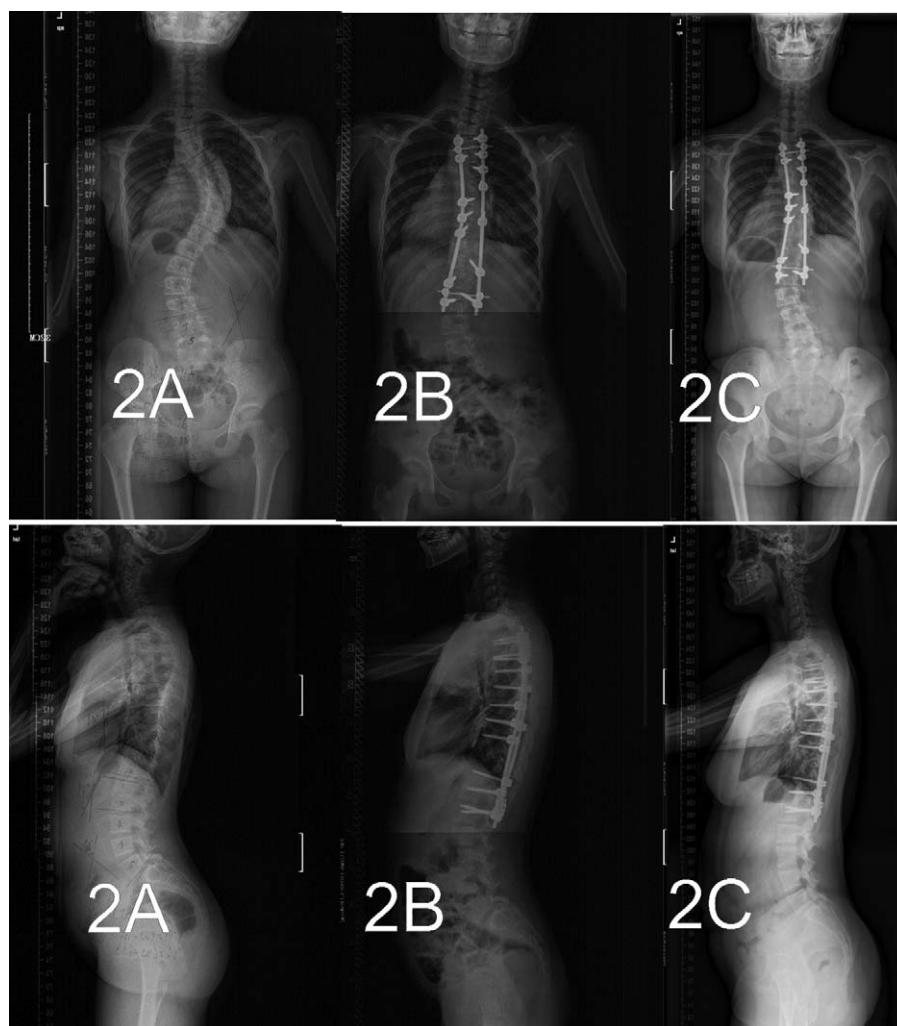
T3 was selected as the upper instrumented vertebrae, preoperative (A), immediately after surgery (B), and final follow-up (C) x-ray films.
